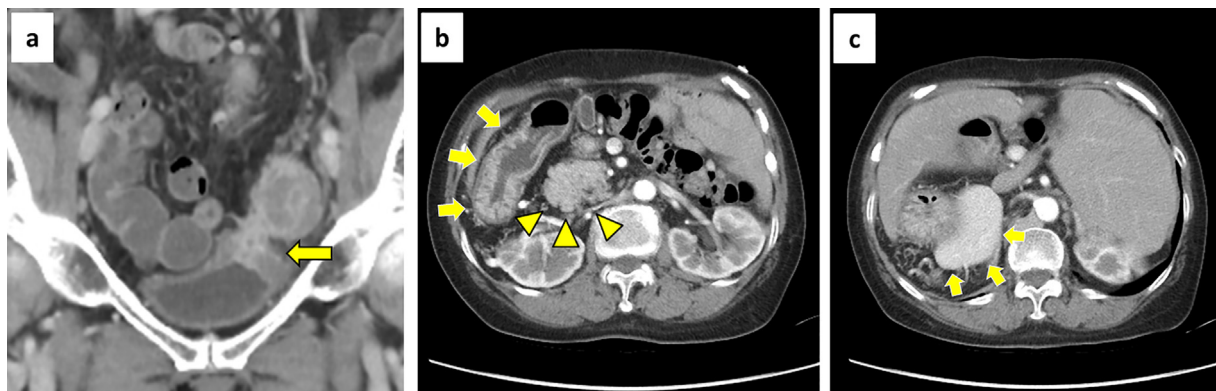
(a) Coronal CT images showing a thickened wall of the sigmoid colon adherent to the bladder (arrow), and a suspected colovesical fistula. (b) Abdominal CT showing stomach (arrow) and pancreas (arrowhead) transposed to the right side. (c) Abdominal CT showing the spleen on the right (arrow).
